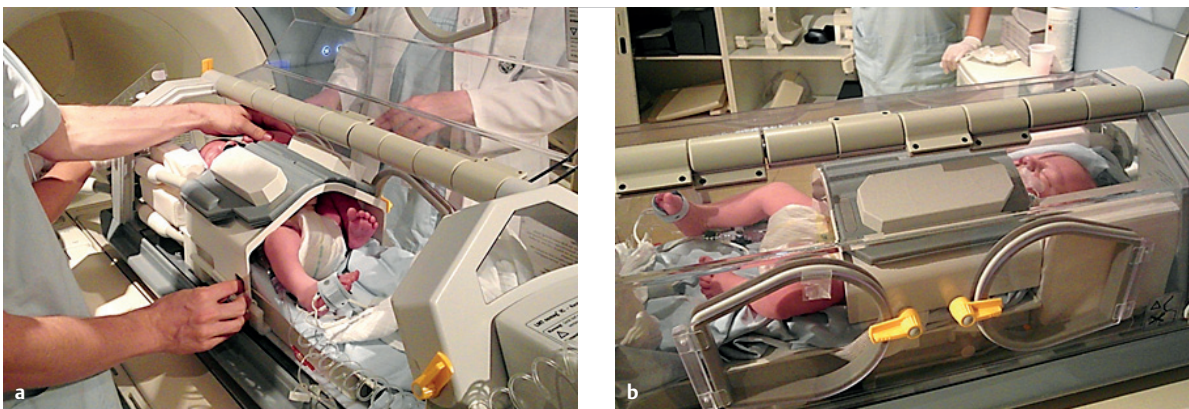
MRI-compatible incubators used with multi-channel body coils. Nomag incubator (manufactured by LMT Medical Systems). 20-day-old, mature male newborn.
